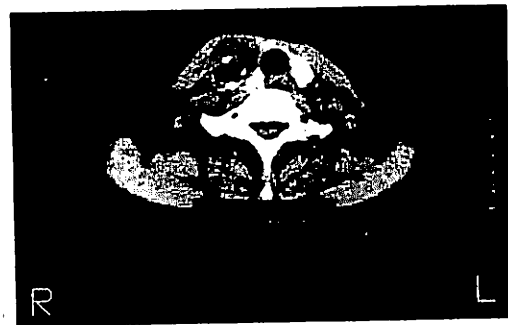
X-ray CT scan shows a huge low density mass with egg-shell calcification in the right lobe of the thyroid.
